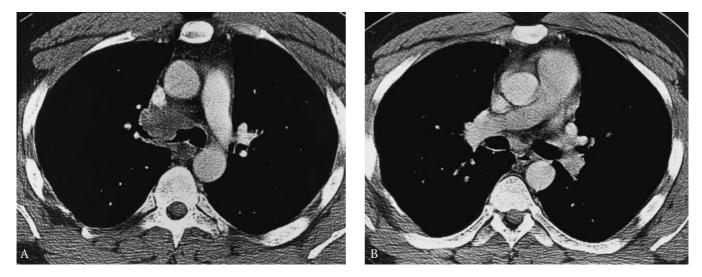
A, Computed tomography (CT) scan showing a right mainstem bronchial tumor and compression from a metastatic sarcoma. B, CT scan showing a clear bronchus intermedius, confirming a patent distal airway favoring successful stenting.
